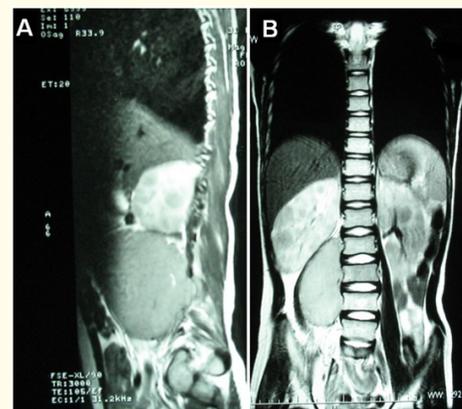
T1/Fatsat-weighted abdominal MRI with gadolinium injection in sagittal (A) and frontal (B) sections: right para-vertebral mass with discretely heterogeneous signal, enlarged and multinodular two kidneys and pancreas.
